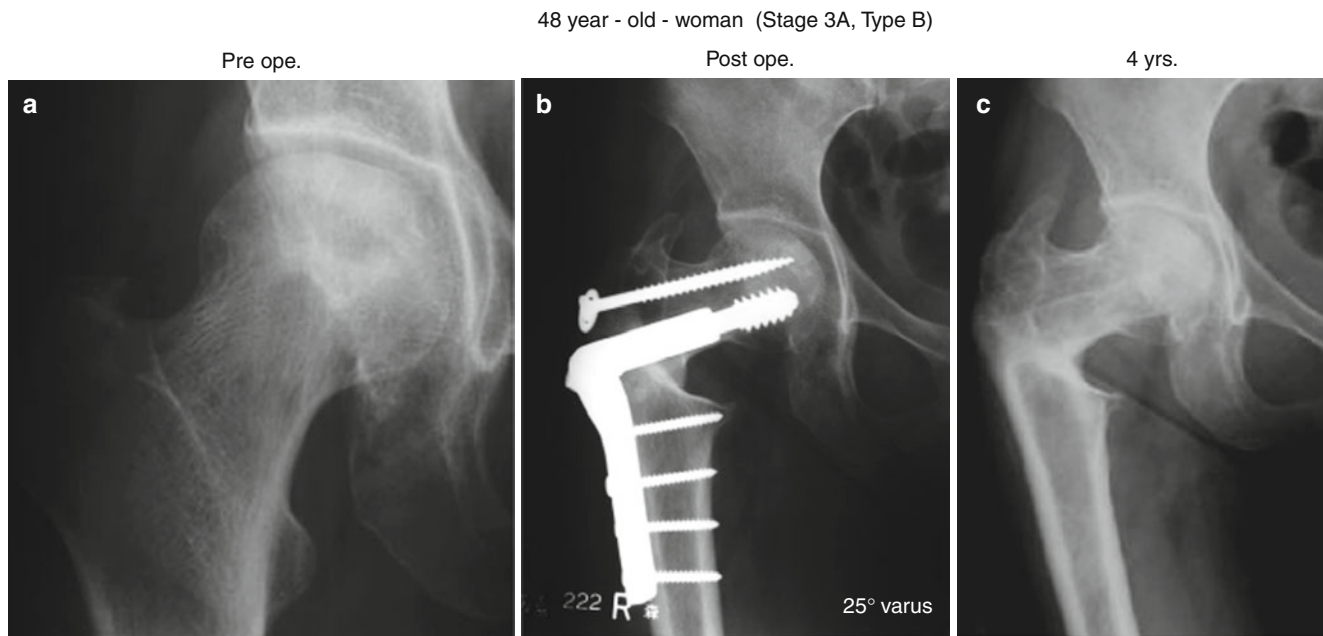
Osteonecrosis in a 48-year-old male. (a) Preoperative radiograph. The right hip was classified as stage 3A and type B. (b) Postoperative radiograph. After 25° of varus osteotomy, an 80 % postoperative intact ratio was obtained. (c) Radiographs 4 years after
